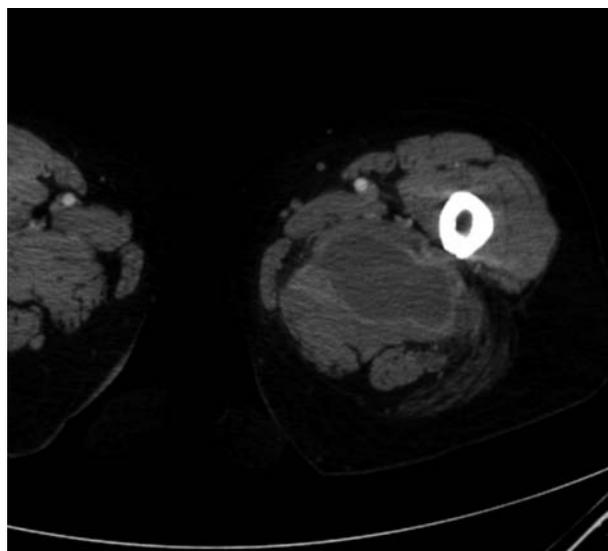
CE-CT, 12 days post-op, prox. left upper leg, transverse.
